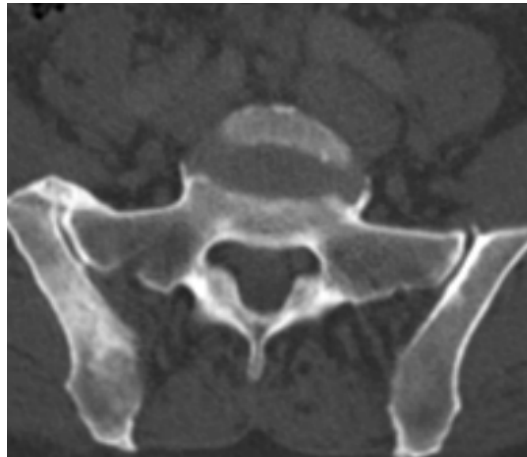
The human skeleton does not develop in exactly a symmetric way. The bone within this CT slice is not perfectly symmetric, and this lack of symmetry is likely due to development as well as to disease. Additionally, the slice angle could be another cause of asymmetry with CT images. The CT data is from the Addenbrooke's Hospital CT Data Collection.
